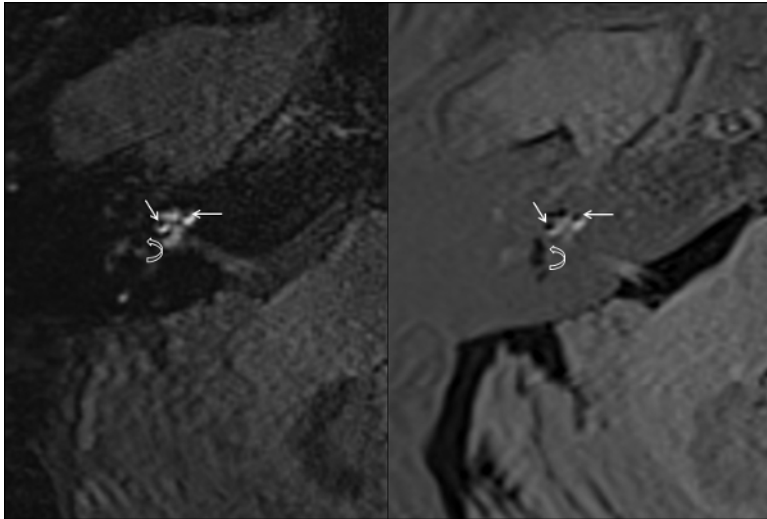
Endolymphatic hydrops in MRI scans. High grade endolymphatic hydrops of the cochlea (straight arrows) and the vestibule (curved arrows) in 3D-FLAIR (A) and 3D-Real-IR (B). [Please click here to view a larger version of this figure.](#)
